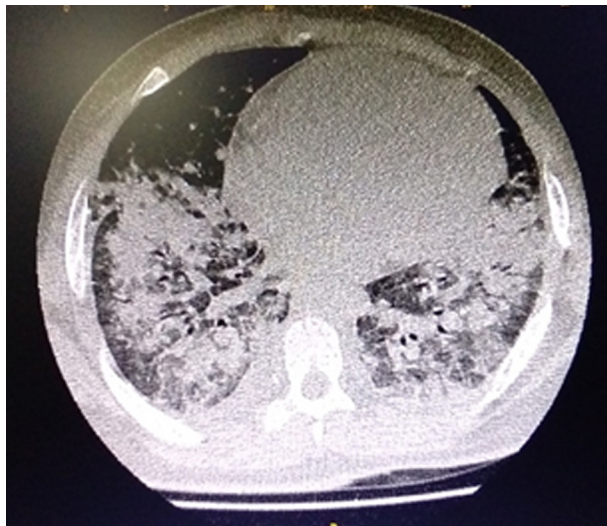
Computed tomography (CT) image on admission showing bilateral symmetrical opacities
